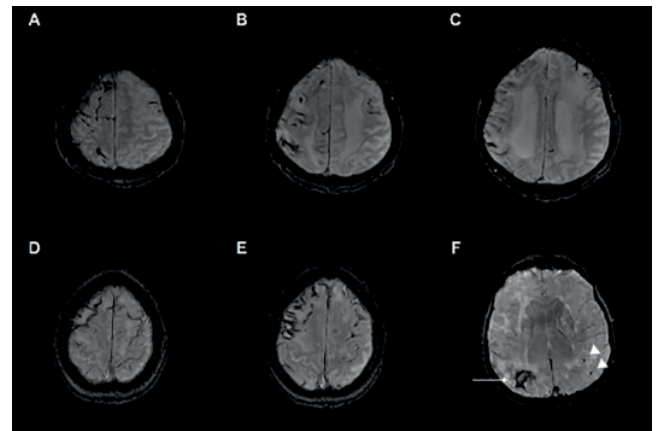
1.5T axial brain MRI, T2* GRE sequences. Disseminated cortical superficial siderosis (CSS) in a 66-year-old female patient (A-C) and 74-year-old male patient (D-E); F: A right lobar intracerebral hemorrhage (white arrow) in a 77-year-old male patient, with two lobar (cortical and cortical-subcortical location) microbleeds (arrowheads).
